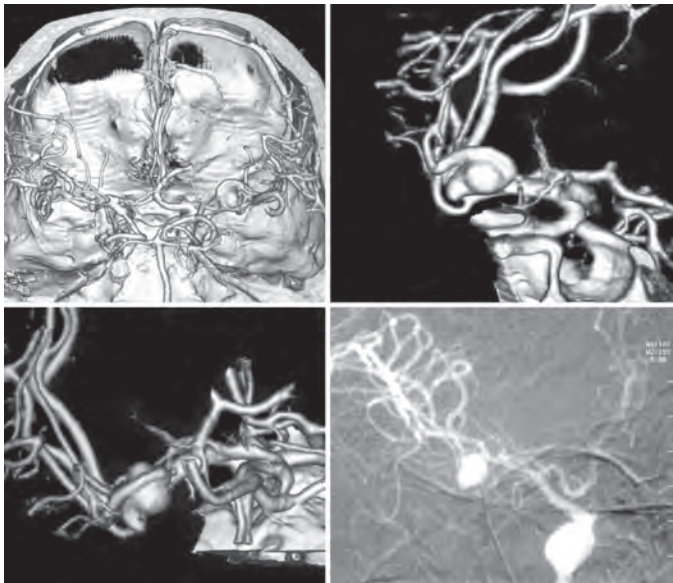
CTA and DSA—MCA bifurcation aneurysm. Showing one M2 branch behind the aneurysm
